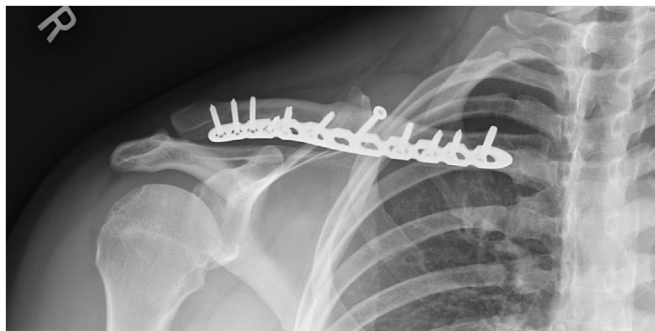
Postoperative plain radiographs 5 months following surgery depict a healed clavicle osteotomy with restoration of anatomy.
